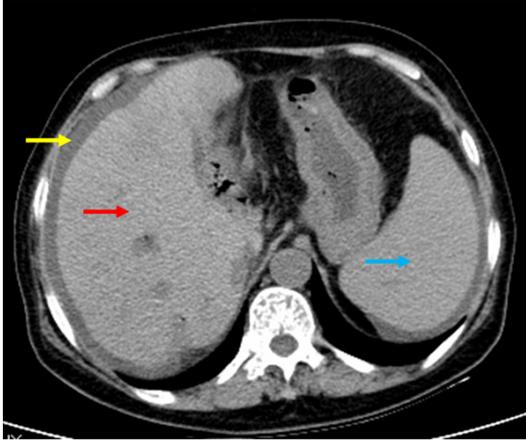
Abdominal computed tomography scan showing heterogeneity of the liver (red arrow), splenomegaly (blue arrow), and a small amount of ascites (yellow arrow).
